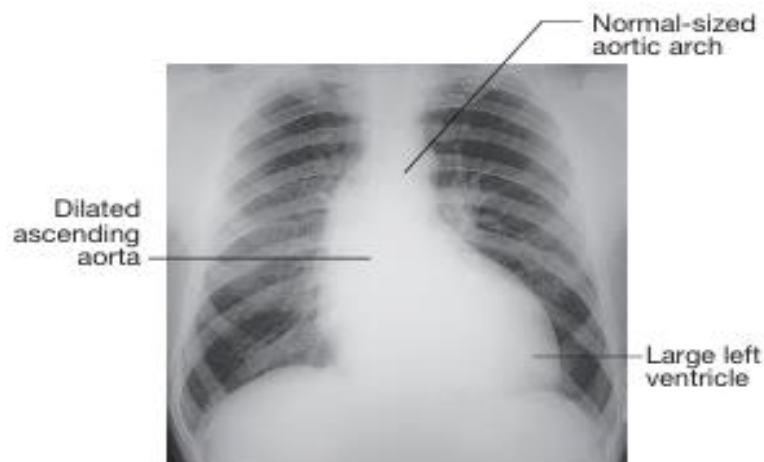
Chest X-ray of a patient with aortic regurgitation, left ventricular enlargement and dilatation of the ascending aorta.<sup>[40]</sup>
